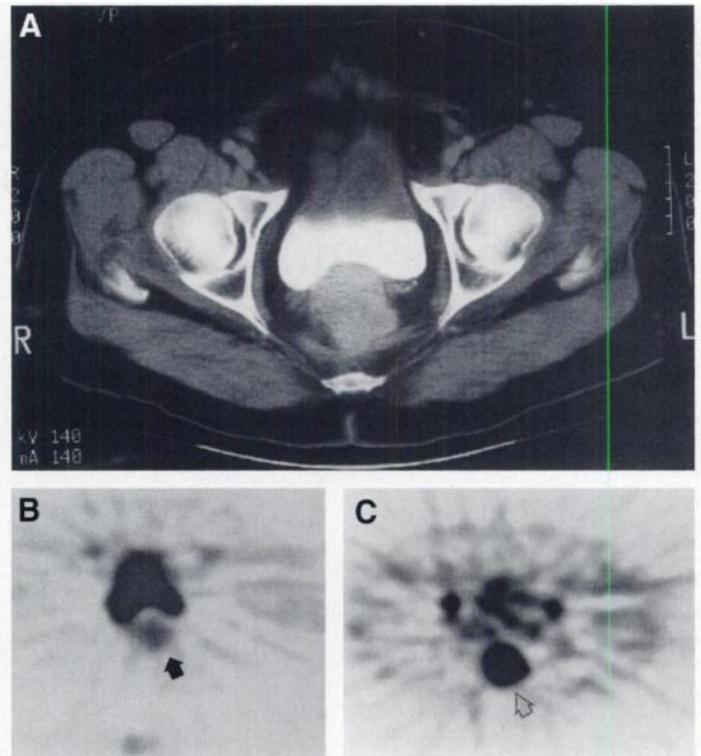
(A) CT demonstrates a mass lesion posterior to the urinary bladder. (B) FDG-PET scan shows a faint activity in the lesion (broad arrow). (C) Met-PET scan reveals more intense uptake in the lesion (open arrow) and less uptake in the urinary bladder than the FDG-PET scan. Chemotherapy markedly reduced the size of recurrent colon cancer.
